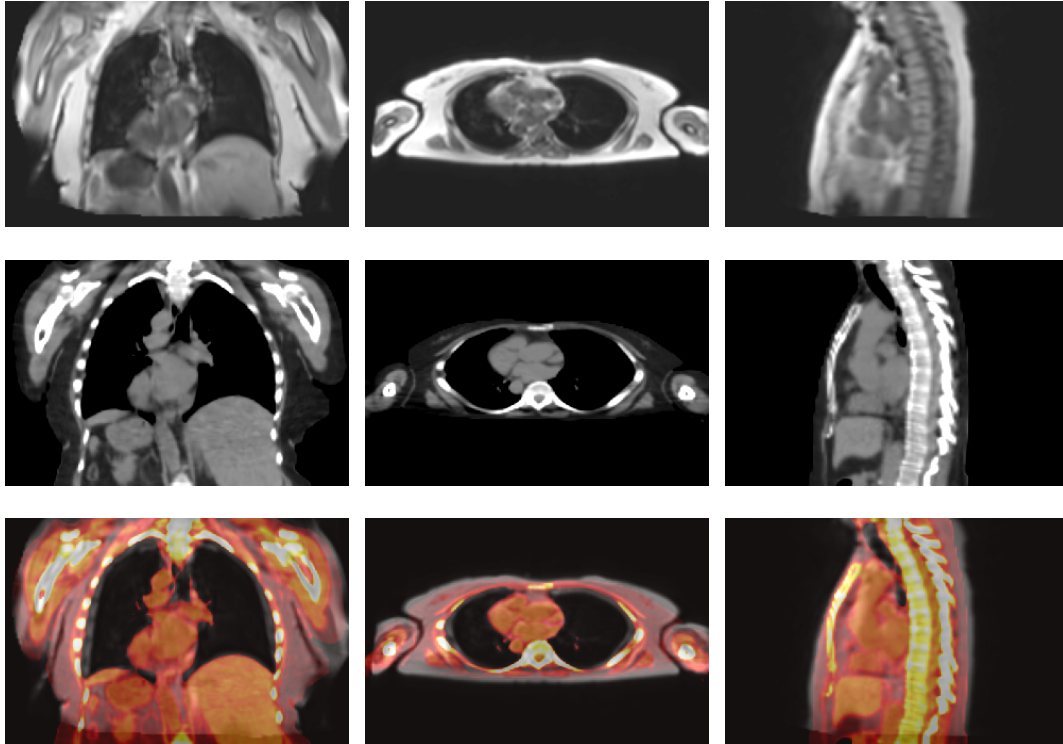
Images in template space after complete preprocessing and registration. Top row: MR (In-Phase) images showing coronal (left), axial (middle), and sagittal (right) views. Middle row: Corresponding CT views in the same template space. Bottom row: Overlay visualization of CT (hot colormap) on MR (grayscale), demonstrating the spatial correspondence achieved between modalities.
